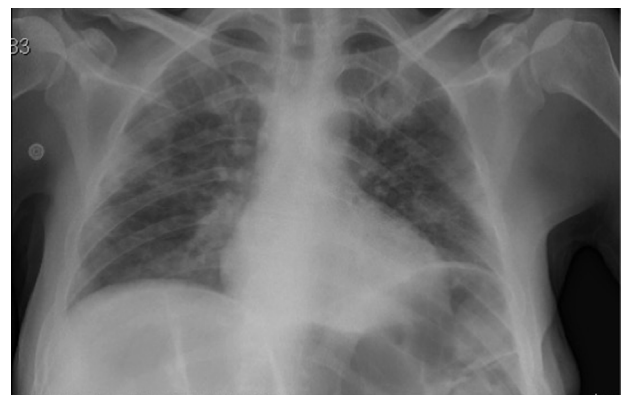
Chest radiography showing bilateral pulmonary infiltrate.
